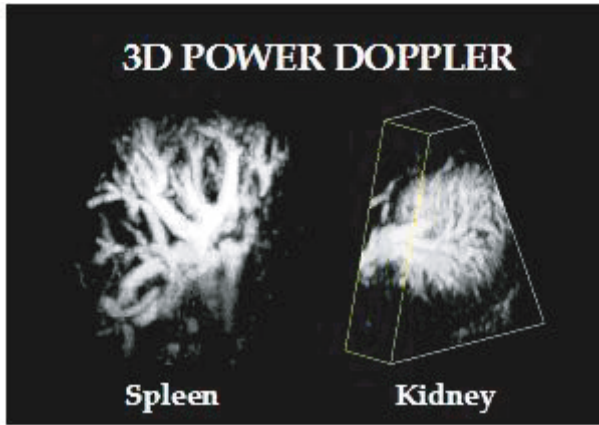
Two 3D power Doppler images obtained with free-hand scanning without position sensing and displayed using volume rendering. On the left is a spleen and on the right, a kidney.
